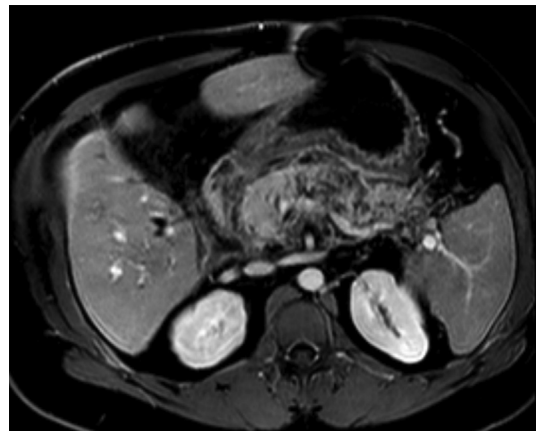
A 37-year-old man with history of recurrent alcohol-induced acute pancreatitis presents with severe epigastric pain with associated nausea and vomiting of 3 days' duration and elevated lipase. Axial T1-weighted fat-saturated postcontrast MR image demonstrates hypoenhancement of the pancreatic body and tail, consistent with pancreatic necrosis. No acute necrotic collection was seen.
